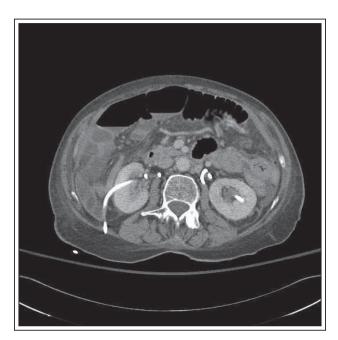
Abdominal CT displays right percutaneous nephroureteral stent coursing through a portion of small bowel.
